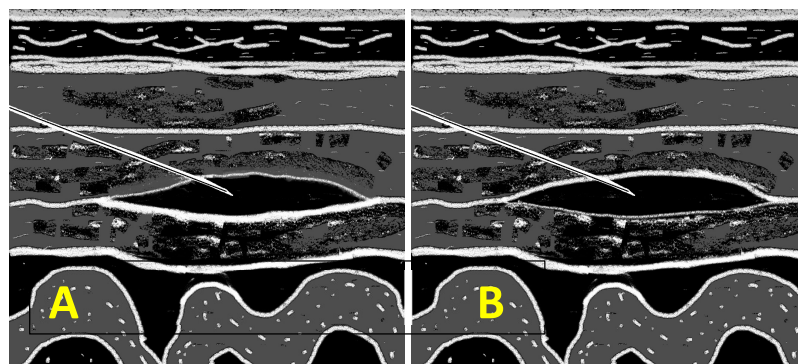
Sketch sonograms of the TAP space filled with injected local anesthetic drug. In image A the fluid is above the TAP fascia. In image B it is below the TAP fascia.
